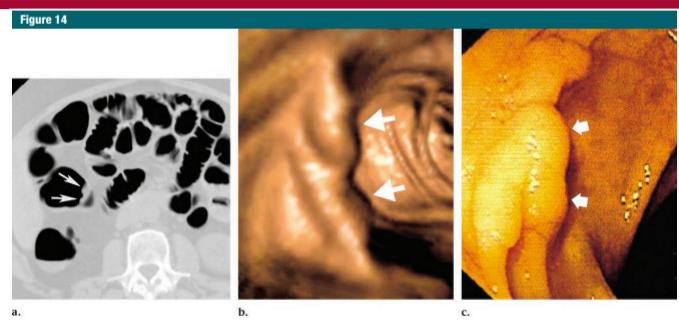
Large (23-mm) sessile lesion missed by many readers at CT colonography. (a) Axial image reveals only a portion of the lesion (arrows). (b) Endoluminal view better depicts overall morphology and length of the lesion (arrows). (c) Corresponding colonoscopy image correlates well with b. Arrows = lesion (images from reference 122).
